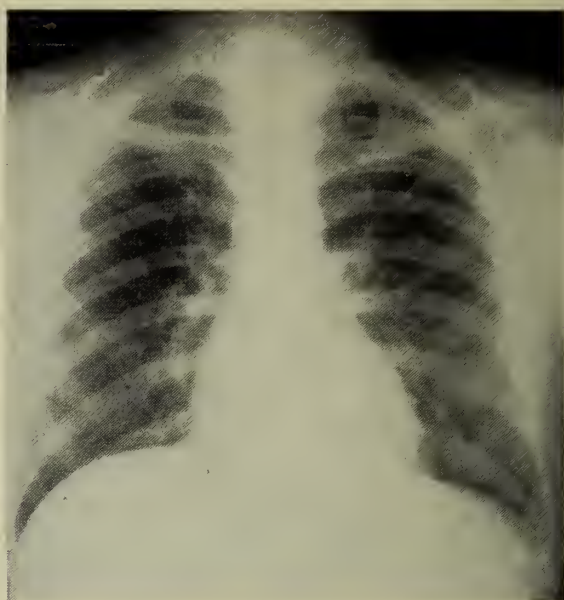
(Case 1) Routine chest X-ray on the 36th hospital day showing a normal cardiac silhouette and clear lung fields.
